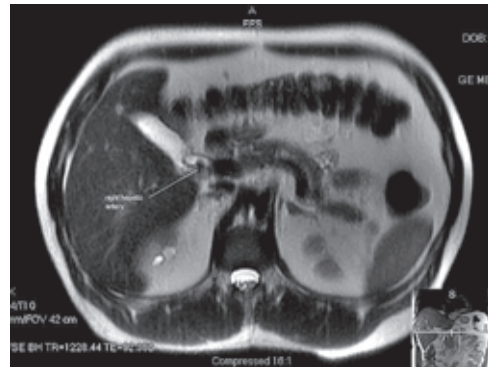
Reanalysis of the MRI T2-weighted images shows a vascular structure (dark) impinging on the bile duct (bright).
